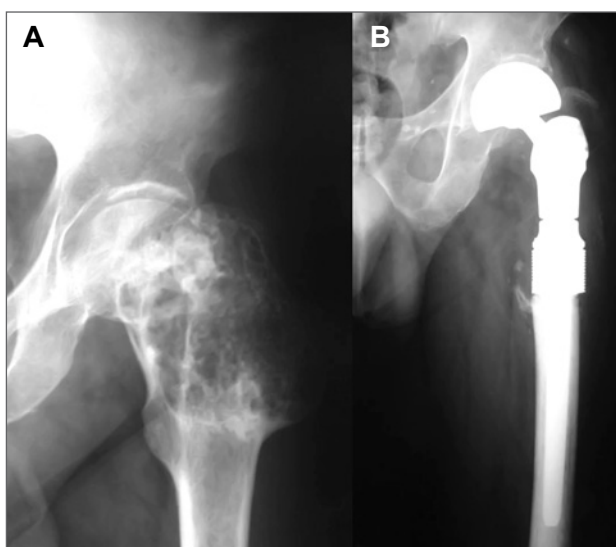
A: Radiograph of the left hip of a 49-year-old man with a recurrent giant cell tumor of the proximal femur (Patient 26). B: *En bloc* tumor resection and reconstruction with a bipolar proximal femoral megaprosthesis was done; 14 months postoperatively, there is no evidence of local tumor recurrence.
